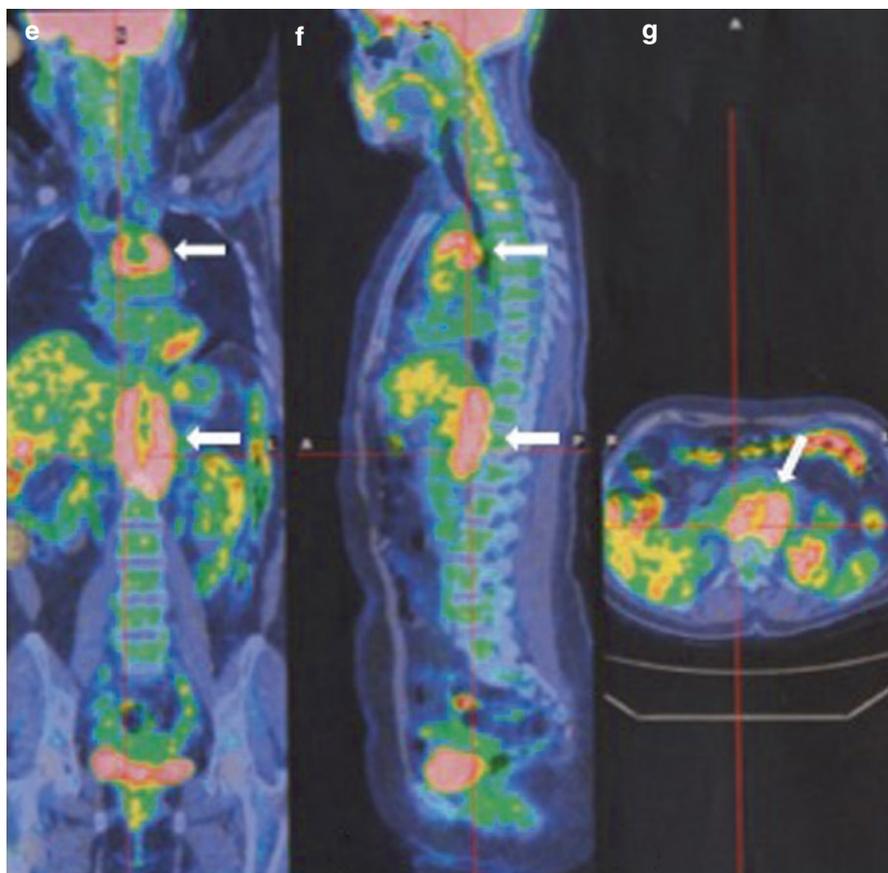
(Continued) (e–g) ^{18}F -Fluorodeoxyglucose (FDG) positron emission tomography (PET)-CT evidence of active chronic periaortitis. The scans (e), coronal view, (f), sagittal view, and (g) axial view show increased uptake of FDG at the thoracic aorta and upper abdominal aorta levels (arrows)
